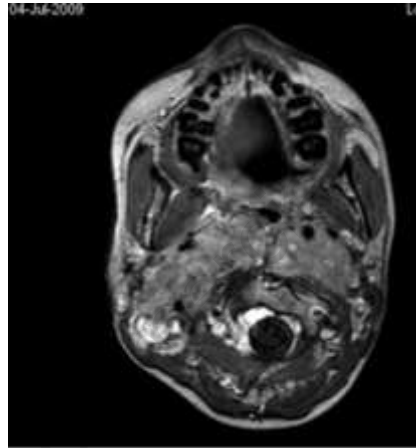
Neck MRI nine months post treatment.
